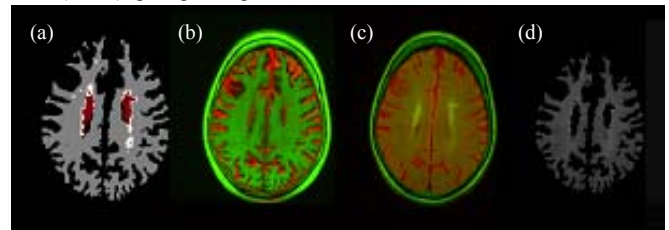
(a) Masks of NAWM, iWMLs (red) and liWMLs (white); (b, c) fused T₁W and T₂W, and T₂*W and FLAIR volumes in RG colour space; (d) NAWM and liWMLs in FLAIR.
